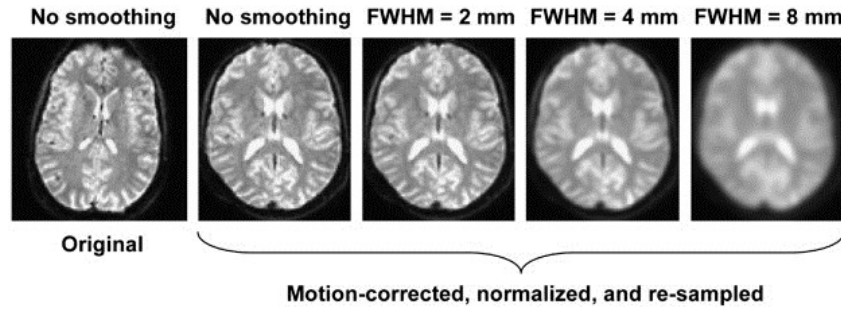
[48] The process of smoothing the image influences the data to become more normally distributed, however, the larger the kernel, the more spatial precision is lost. (From left to right) This figure demonstrates the original MR image before preprocessing and smoothing; after preprocessing (normalization, segmentation and modulation using SPM5) but still no smoothing; smoothing with a Gaussian kernel of three varying sizes (FWHM= 2mm, 4mm, 8mm) as labeled.
